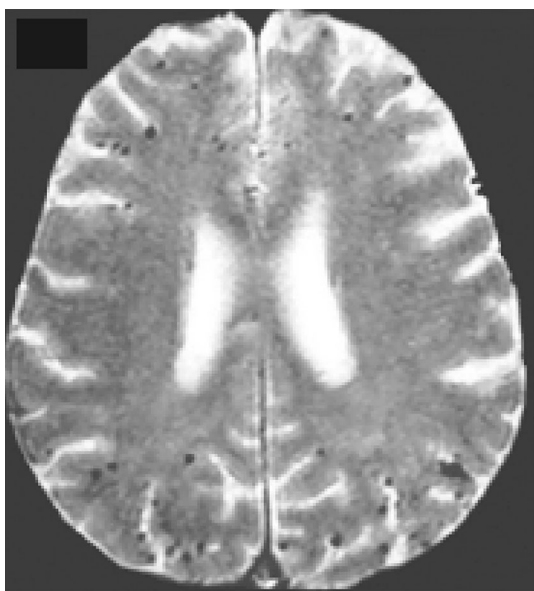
Gradient-echo-T2-weighted (GRE-T2) MRI sequence of small foci of hypointensities. These low signal intensity lesions correspond to cerebral microbleeds
